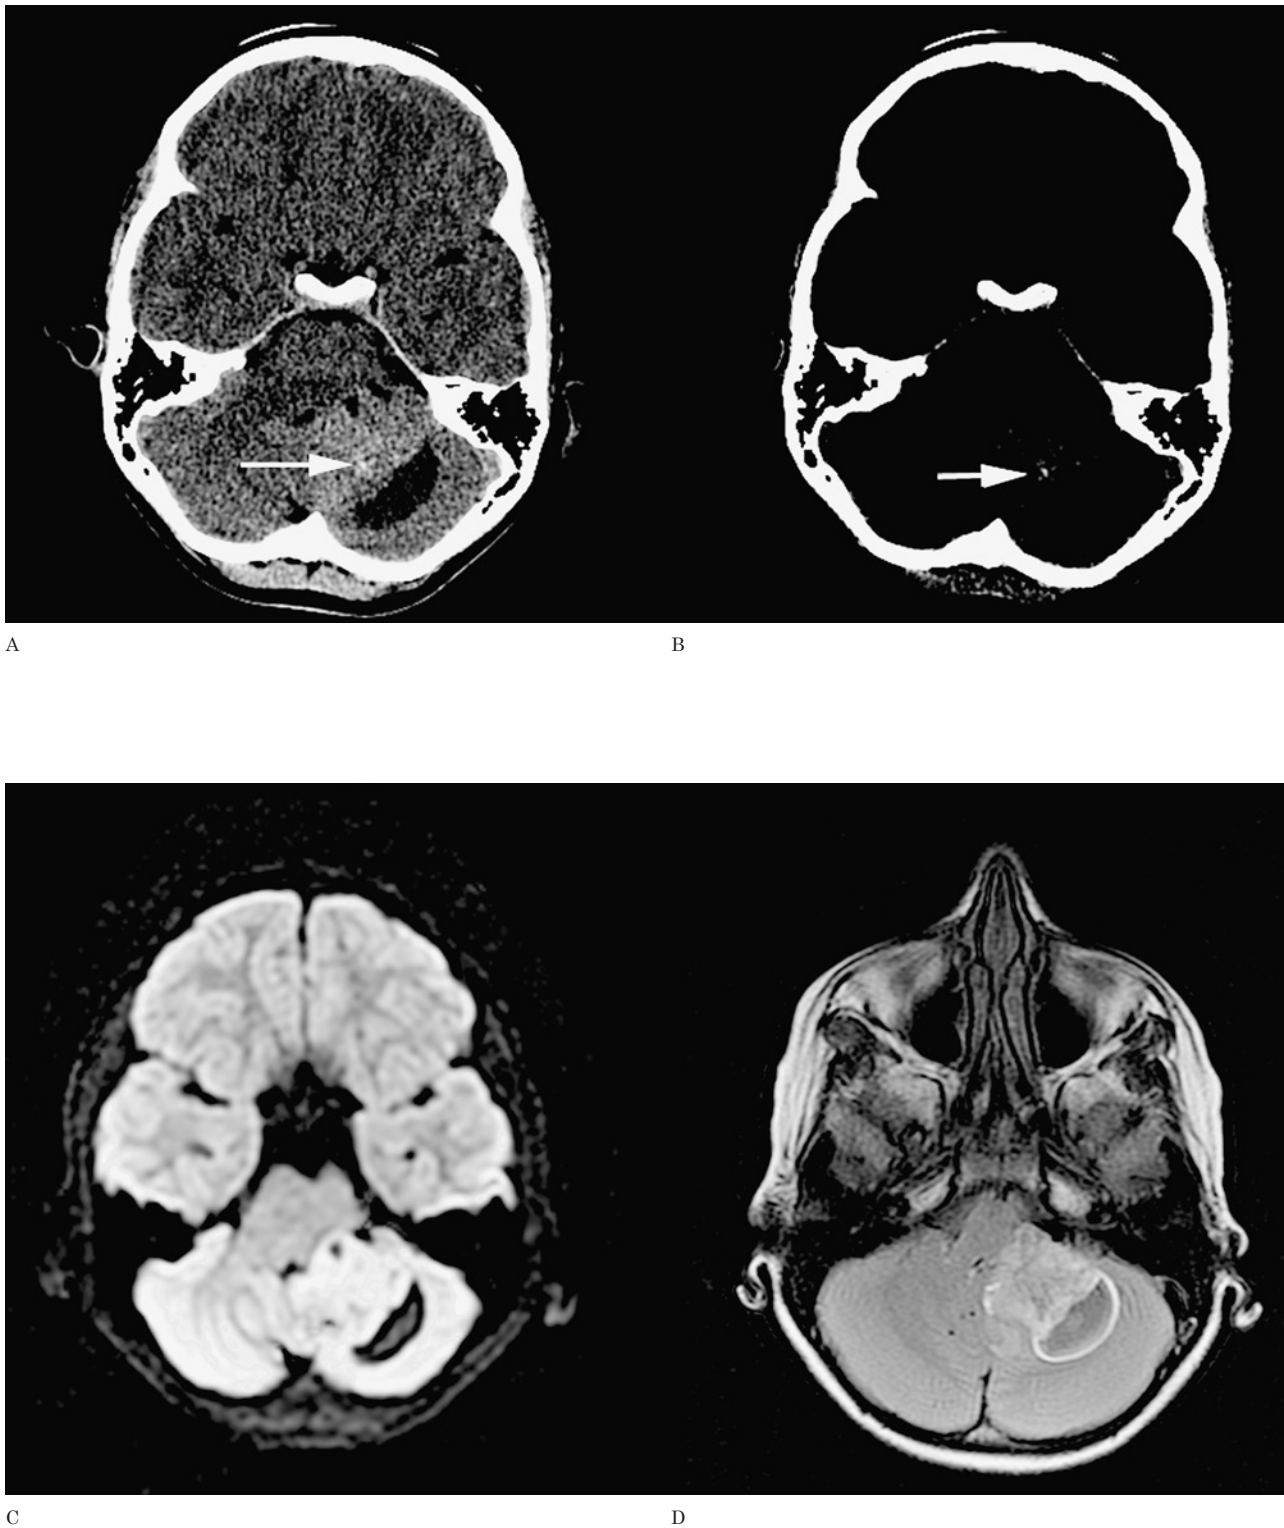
Medulloblastoma (biopsy proven). A-D) Punctate calcifications are seen within a left cerebellar tumour on this non-enhanced CT through the posterior fossa (arrows). C) Diffusion-weighted image demonstrates typical restricted diffusion within the solid component of the tumour. D) Post contrast T1W MR image demonstrates avid enhancement of the tumour.
